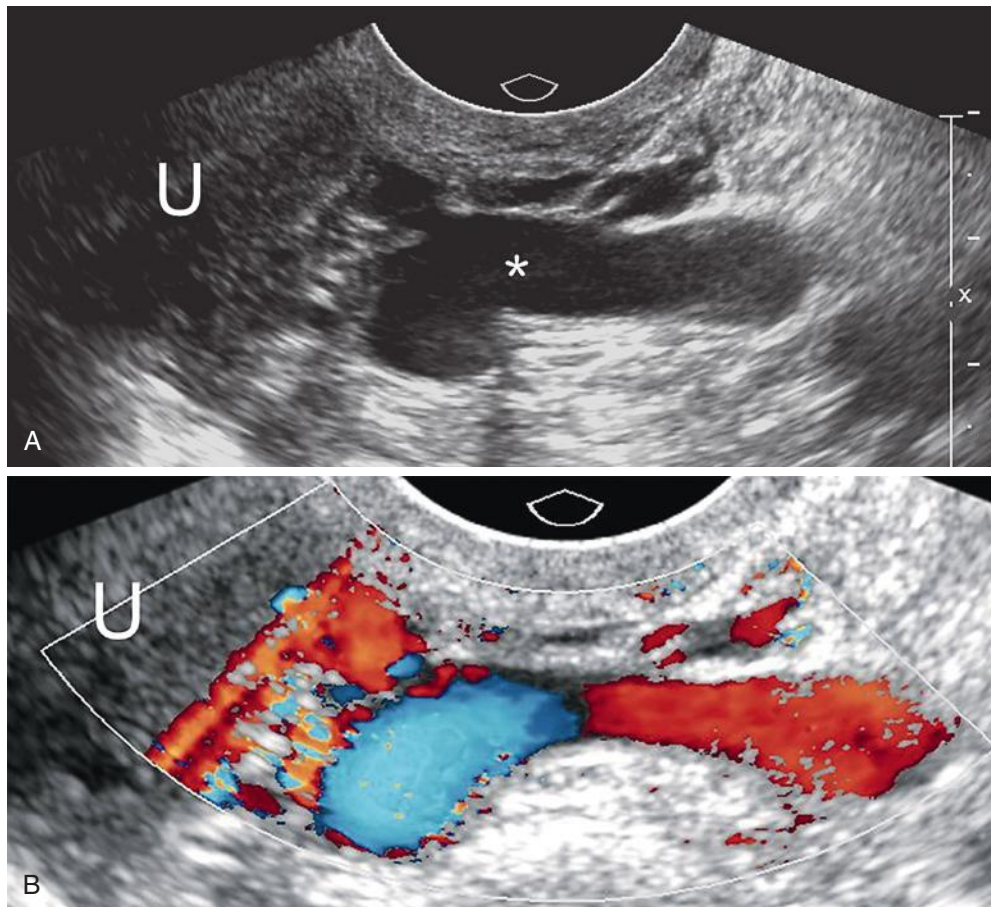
Pelvic varix mimicking hydrosalpinx. A, Gray-scale image demonstrating an anechoic serpiginous tubular structure (*asterisk*) adjacent to the left uterine cornua (U) that could easily be mistaken for a hydrosalpinx. However, color Doppler imaging (B) demonstrates that the structure fills in with color, consistent with a pelvic varix. Uterine cornua (U). (From Baltarowich OH, Scoutt LM: Avoiding pitfalls in transvaginal sonography of the female pelvis. *Ultrasound Clin* 5:177-193, 2010, used with permission.)
